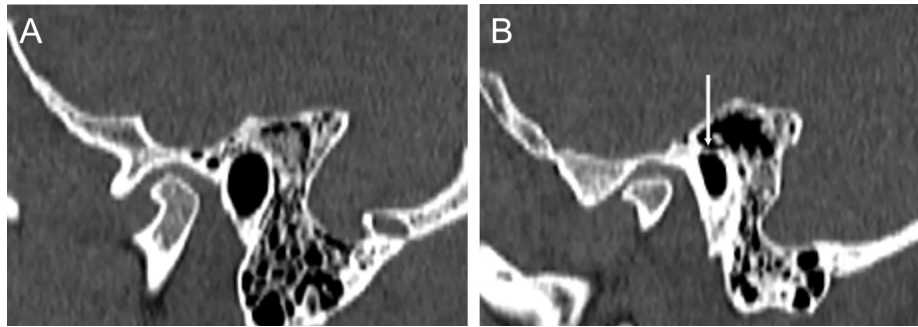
A, B. Reconstructed CT slices show that (A) the beginning of the osseous external ear canal, first slice where the external ear canal with bone; (B) ending of the osseous external ear canal, annulus of the tympanic cavity with Rivinus' notch.
